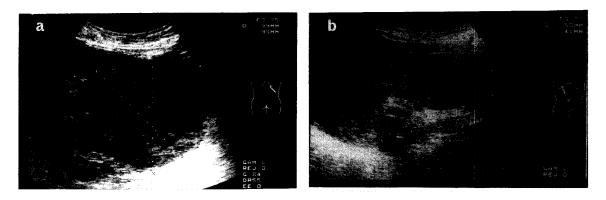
Ultrasonographs of primary (a) and metastatic (b) tumors. (a): A 10-cm tumor with irregular hypoechogenic internal echoes is demonstrated in the right kidney; (b): The lesion in the head of the pancseas shows the same features as the primary lesion.
